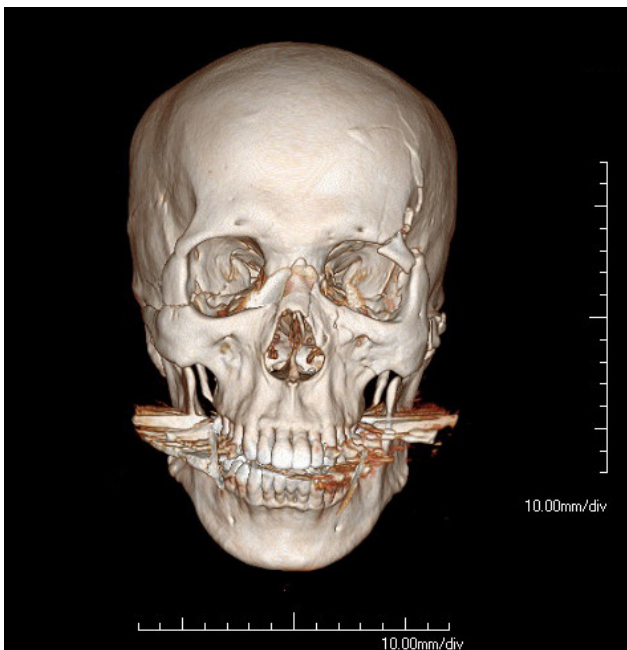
Facial bone 3D CT showed panfacial fracture. CT: computed tomography.
